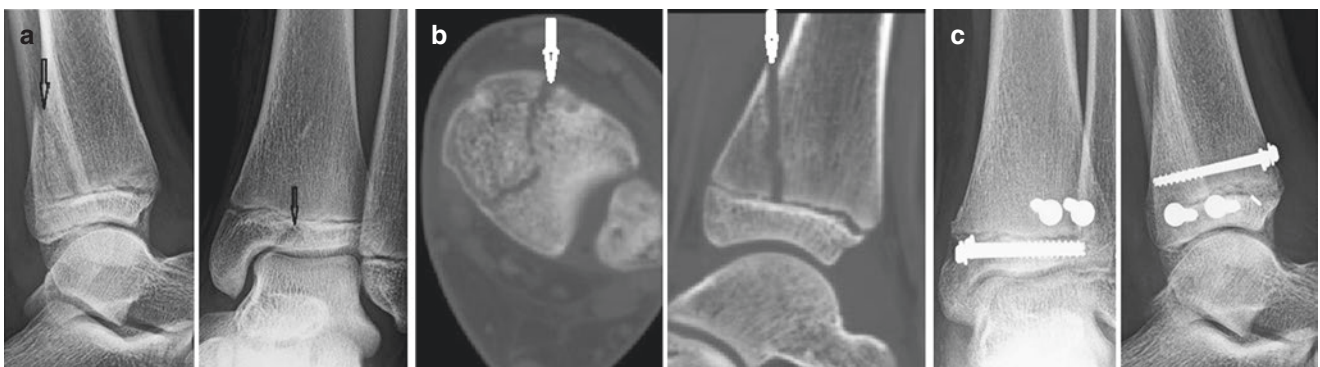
(a–c) Triplane fracture of the distal tibia in 16-year-old High School running back. (a) Lateral and antero-posterior radiograph of left ankle suspicious for Salter-Harris IV (triplane) fracture distal tibia. Not suspected fracture tibial metaphysis and distal tibia epiphysis (black arrows) with possible intra-articular displacement. (b) Axial and sagittal CT image left tibia confirming displaced intra-articular epiphysis
